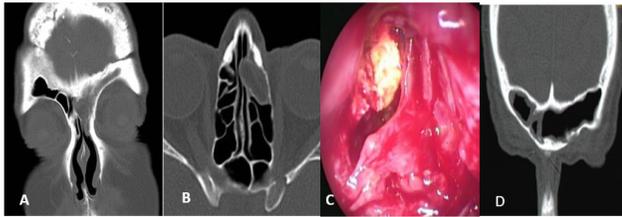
A-B: Computed tomography: a left frontoethmoidal mucocele is observed, C: Endoscopic view of the extraction of the filling material through a frontal approach type Draf II-B, D: Postoperative tomography.
